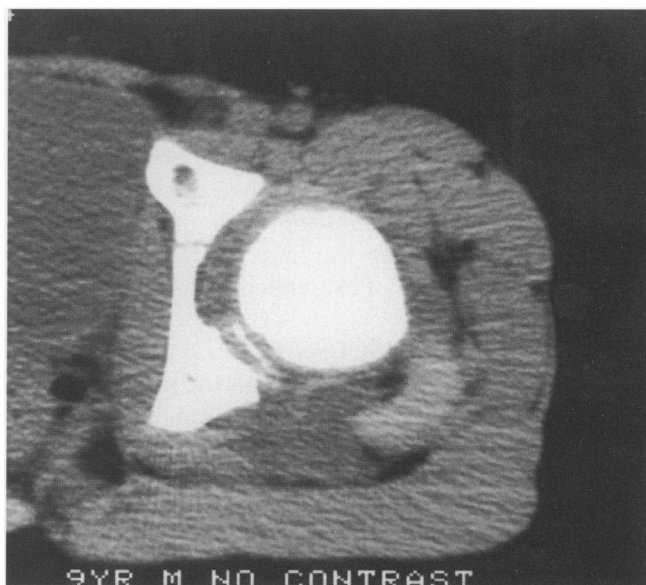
CT scan demonstrating fragment blocking concentric reduction of the femoral head.
